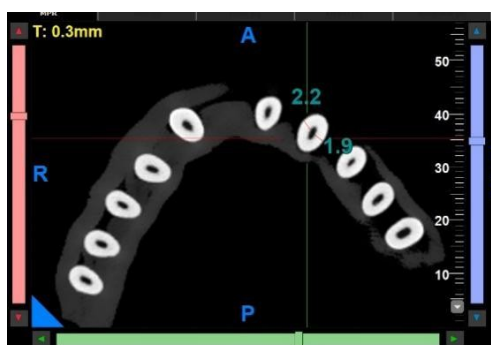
Measurements taken from CBCT
